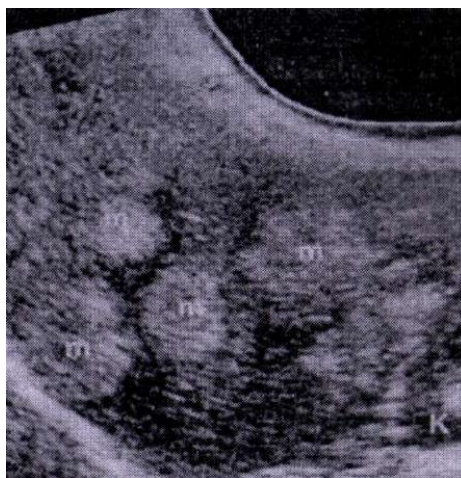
Ultrasound of hyperechoic metastases; primary tumor-colorectal
